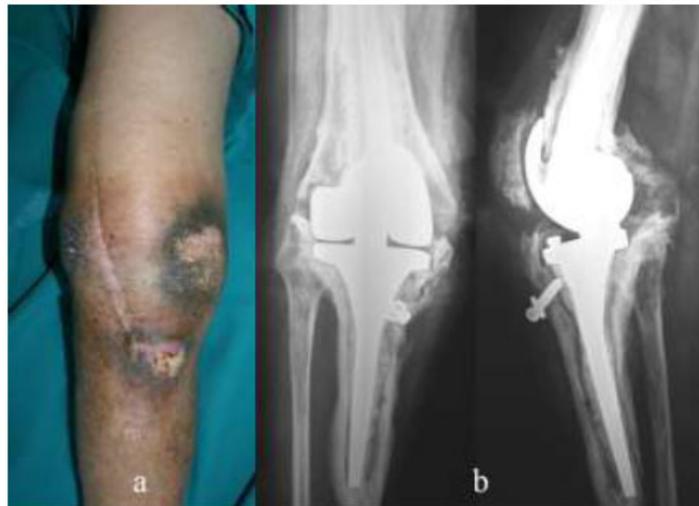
Clinical (a) and radiographic (b) aspects of an infected cemented primary TKA with long stems and high constraint in a 53-years old male affected by severe Haemophilia A with high-titre inhibitors. To note the severe soft tissue mortification and the active sinus tract.
